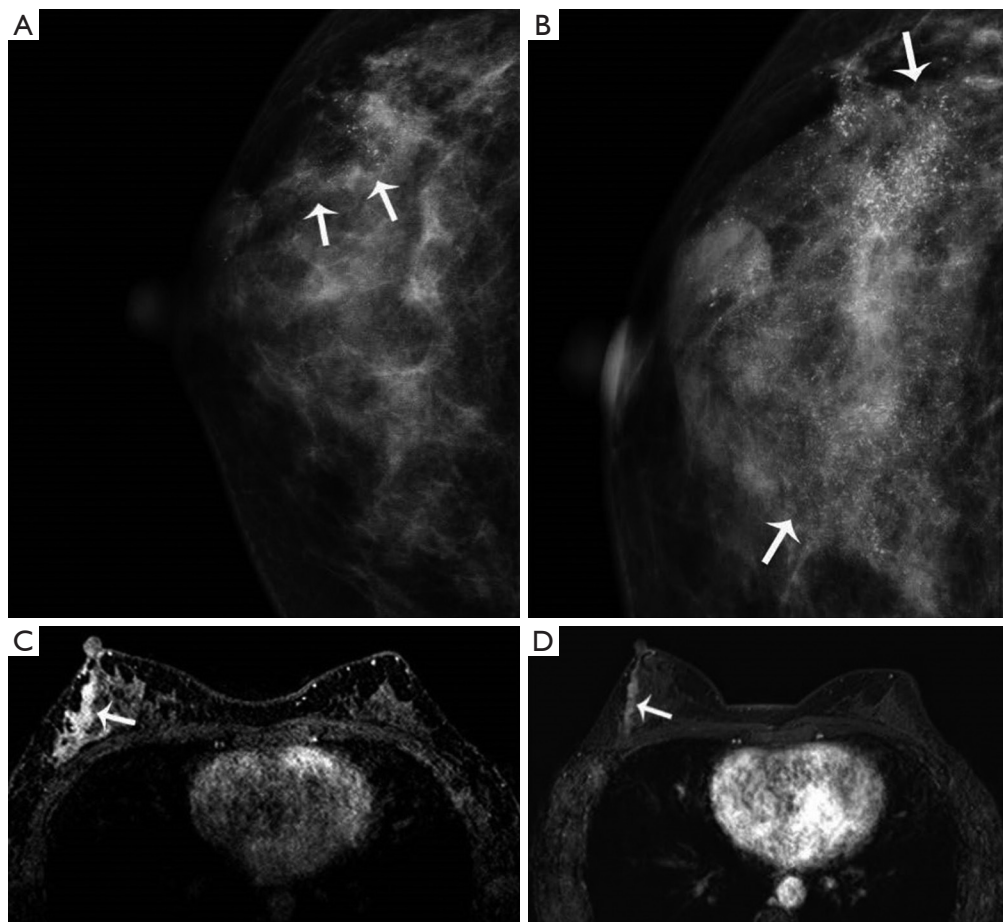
Imaging of a 42-year-old woman in whom a right breast lump was accidentally discovered. (A) Mammogram showing fine pleomorphic segmental calcifications in the right upper outer quadrant before NAT (arrows). (B) After NAT, microcalcifications increased (5.6 cm) (arrows). (C) MRI showing enhancing mass in the right breast (arrow). (D) After NAT, the right breast mass (arrow) decreased remarkably, and the postoperative pathological tumor size was observed to be 1.5 cm. NAT, neoadjuvant treatment; MRI, magnetic resonance imaging.
